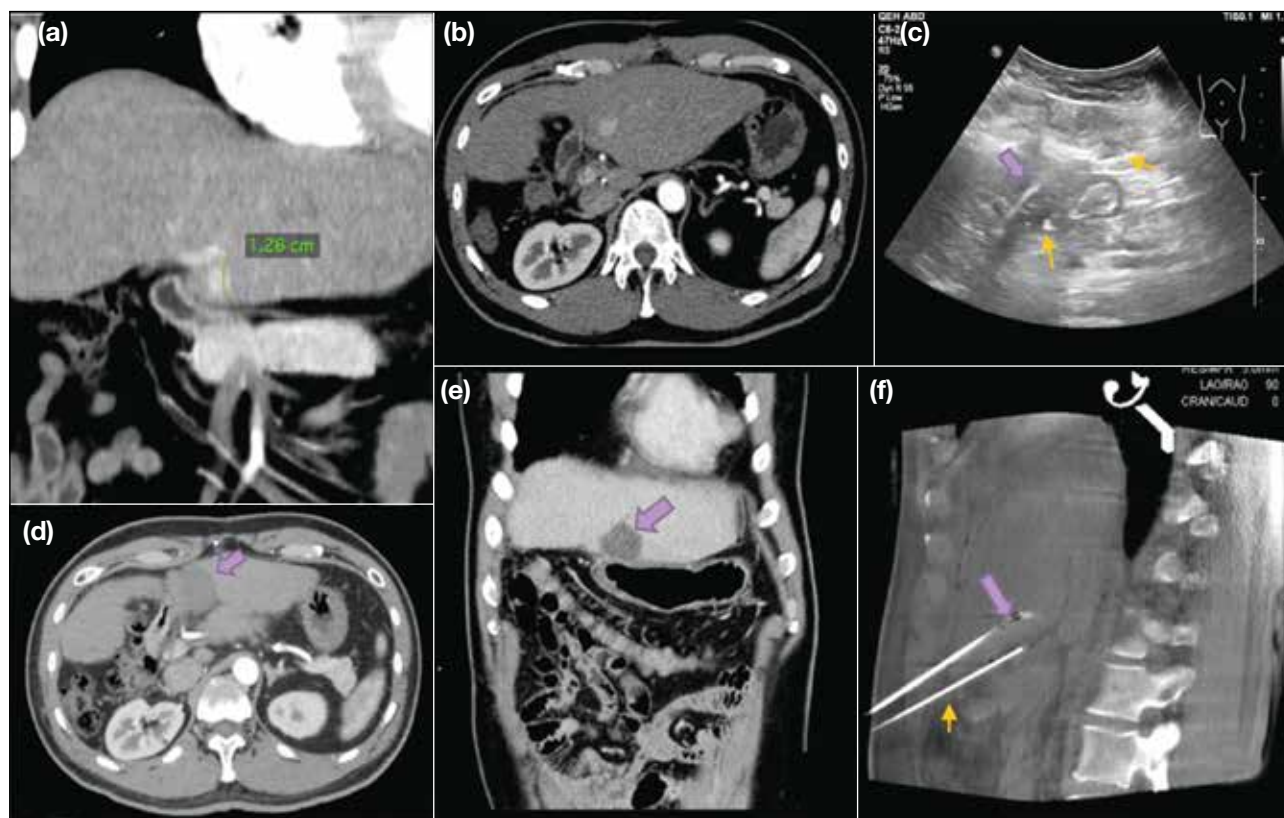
(a and b) Pre-ablation contrast coronal and axial computed tomography (CT) images of the liver showing the segment 3 hepatocellular carcinoma abutting the stomach. (c) Ultrasound image with ablation needle (thick arrow) within the liver lesion, and transgastric insertion of Chiba needle (arrows) into the retroperitoneal space for hydrodissection. (d and e) Post-ablation images 1 month later showing close proximity of the ablation zone (thick arrows) to the stomach and pancreas. (f) DynaCT during the ablation episode showing effective hydrodissection by the inferiorly located Chiba needle (arrow), dissecting away the stomach and pancreas, and successful puncture of target lesion by the microwave antennae (thick arrow).
